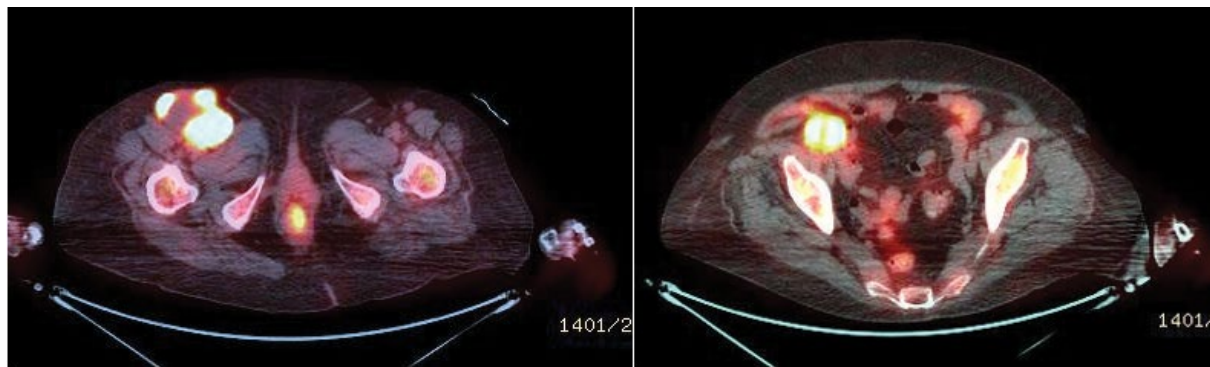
FDG avid tumor lesions in the superficial ipsilateral groin (left) and pelvic iliac chain (right).
